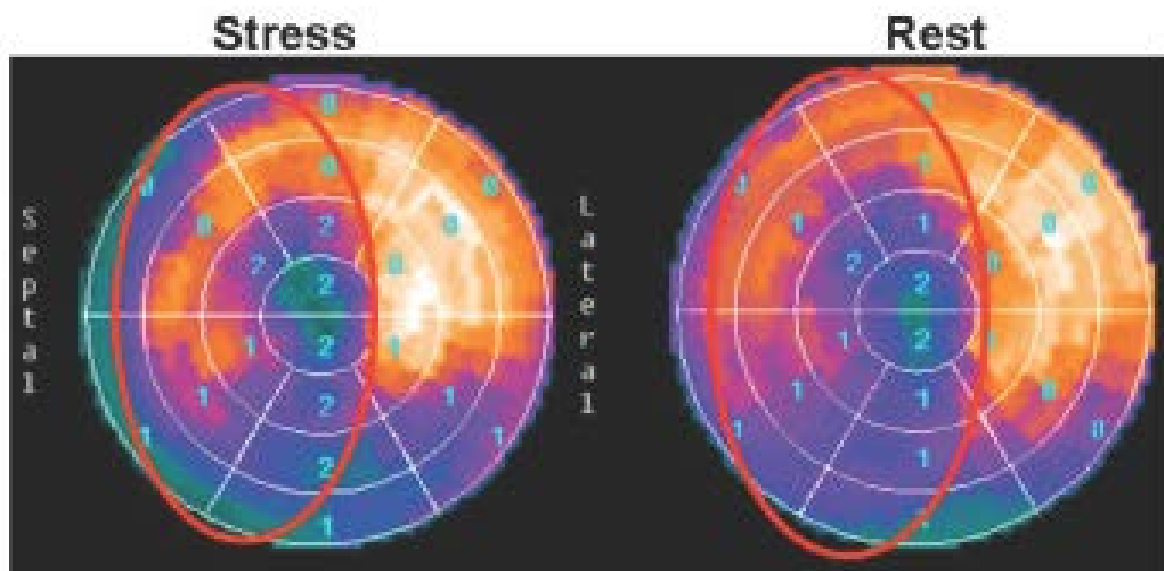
Title - Typical SPECT polar maps of the patient M.
